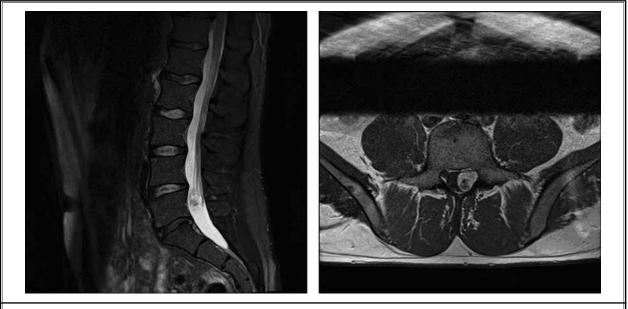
Follow-up T2 weighted lumbar MRI with contrast exhibiting an intradural, extramedullary mass with central necrosis causing thecal sac stenosis with compression of exiting L5 and traversing S1 nerve roots.
